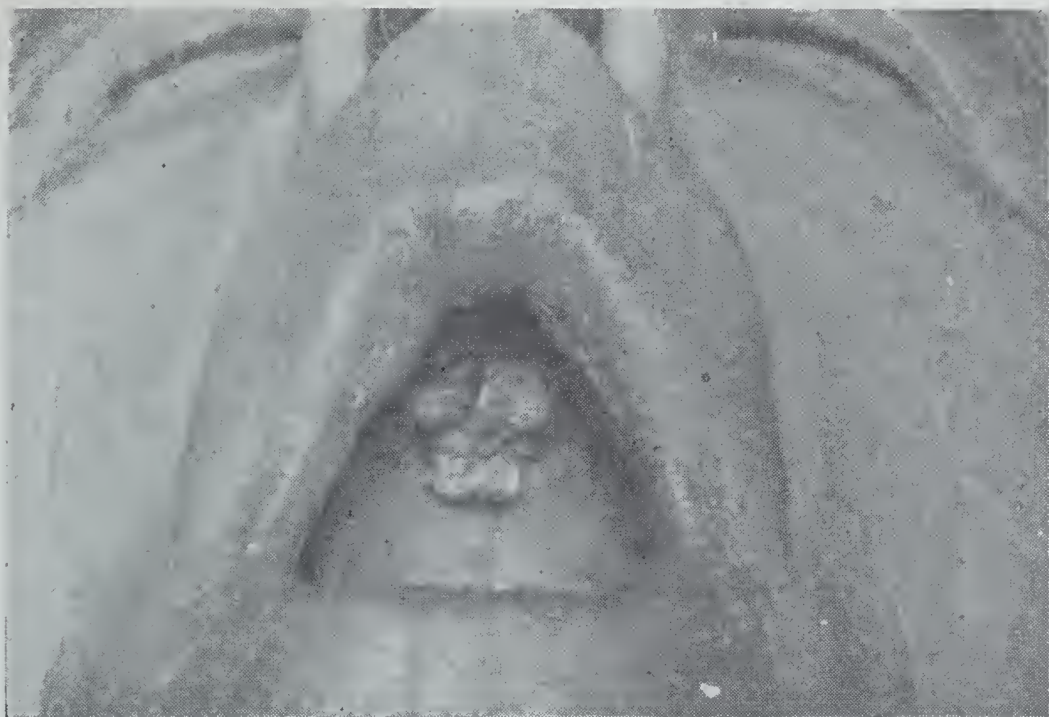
Squamous cell carcinoma involving the mucous membrane of the hard palate treated with intraoral roentgen therapy with no recurrence in ten years.
